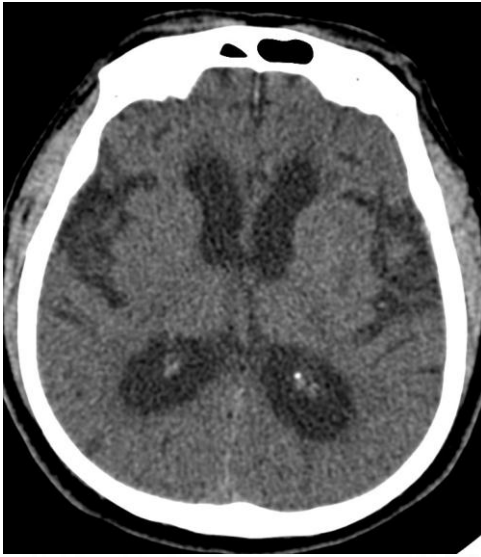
Plain CT (ASPECTS 9)
